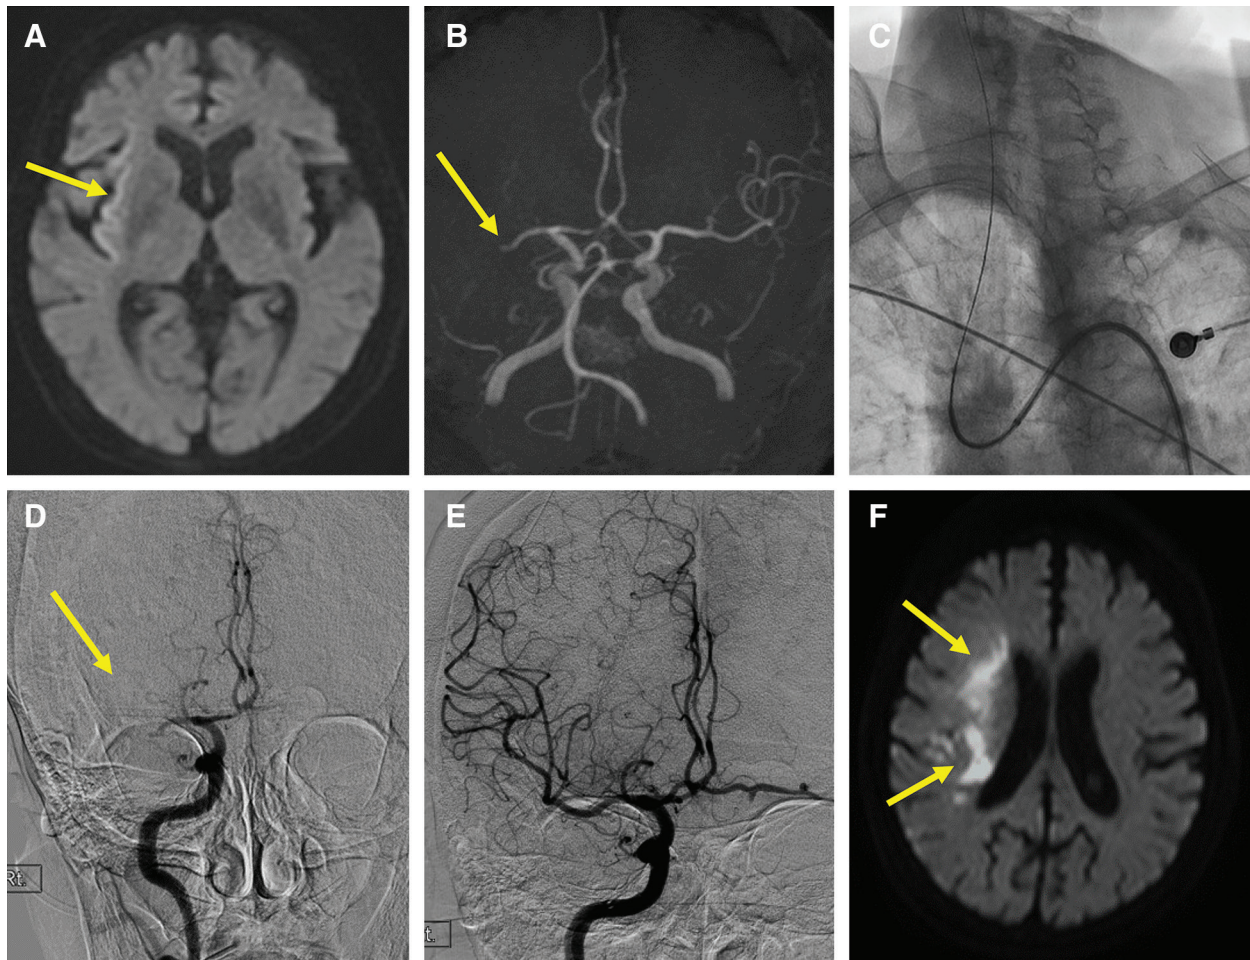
Case 2. (A) Preoperative MRI-DWI. A light high-signal-intensity area was detected in the right insula cortex (arrow). (B) Pre-operative MRA. Occlusion at the distal M1 segment of the right middle cerebral artery was observed (arrow). (C) Frontal view on fluoroscopy. An approach to the right common carotid artery was attempted through the right femoral artery, but the type III aortic arch made it difficult to guide a 9 Fr balloon guiding catheter. (D) Frontal view on angiography. Occlusion at the distal M1 segment of the right
